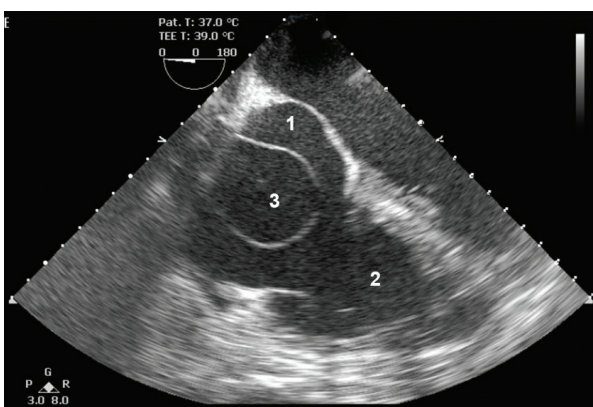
Two-dimensional transoesophageal echocardiogram in short-axis view. 1, right atrium; 2, right ventricle; 3, aneurysmal sac. The windsock arises from the terminal part of the tunnel and is demonstrated within the right atrium.
